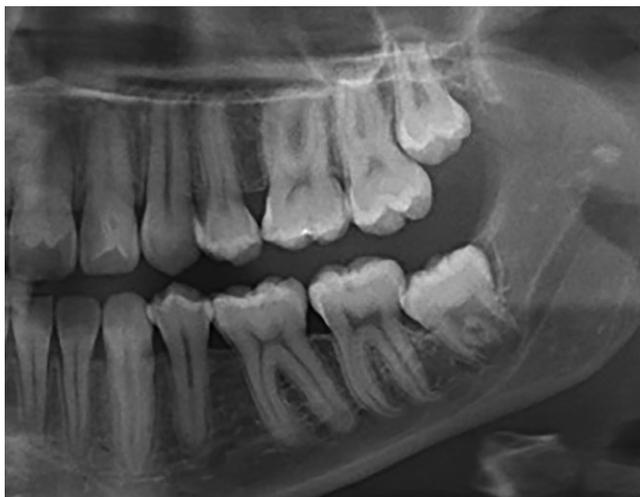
Radiograph of Case 3.
